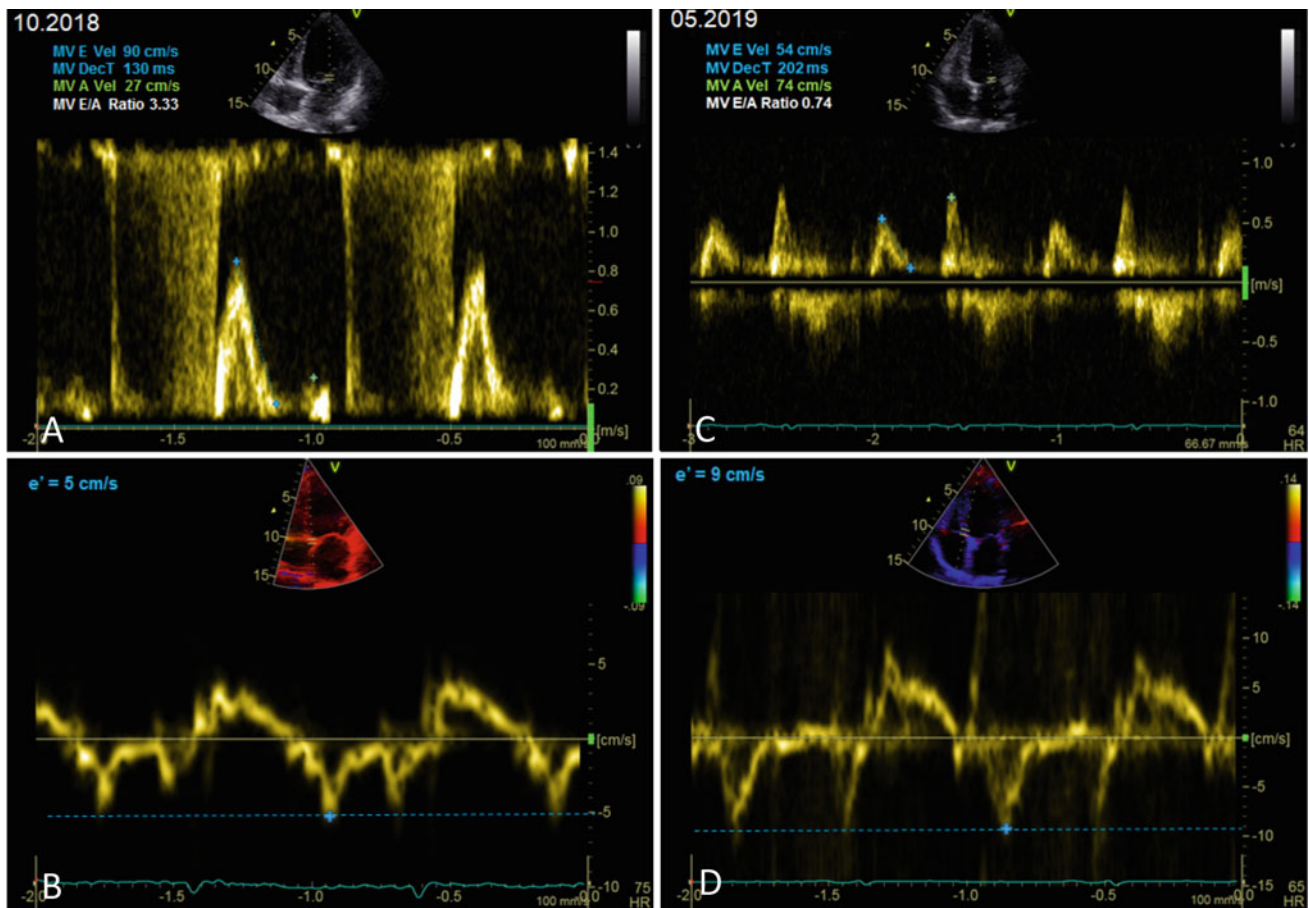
Severe diastolic dysfunction in October 2018 with echo Doppler findings consistent with grade III diastolic dysfunction as characterized by high LV filling pressure with restrictive filling pattern. a Pulsed wave Doppler of mitral inflow with mitral E/A ratio of 3.3 and deceleration time of 130 ms. b Tissue doppler imaging of the mitral
